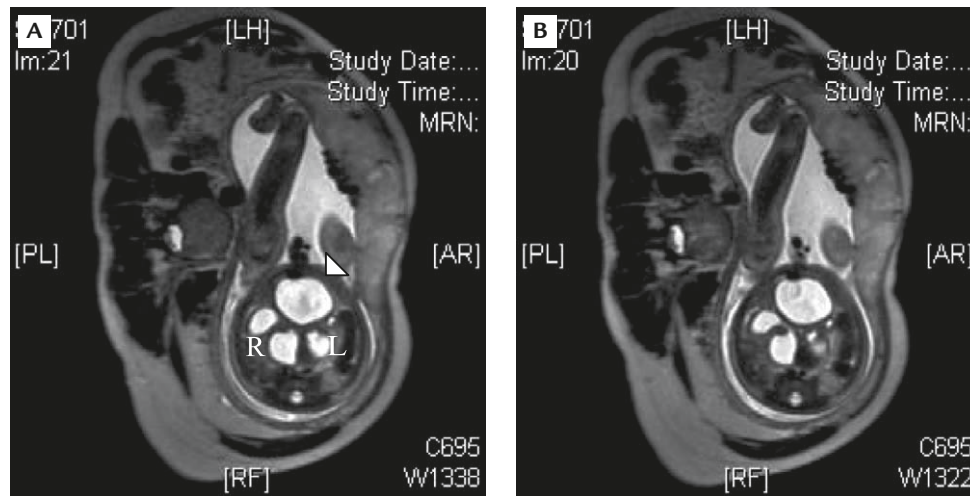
Fetal magnetic resonance imaging at 34 weeks of gestation. T2-weighted image in the transverse view showing: (A) a dilated fetal bladder (arrowhead) in the midline with pelvic cysts posterior to it, indicating right hydrometrocolpos (R) and left hydrocolpos (L); and (B) the communication between dilated vagina and uterine cavity over the right side of the fetus.
